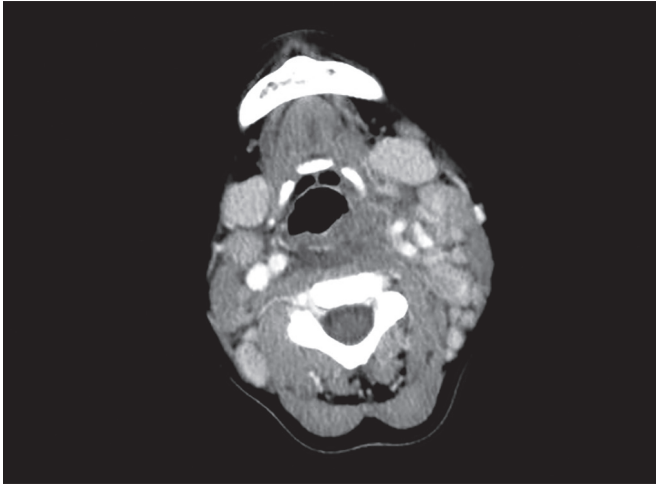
Axial computed tomographic image of a developing retropharyngeal infection.
